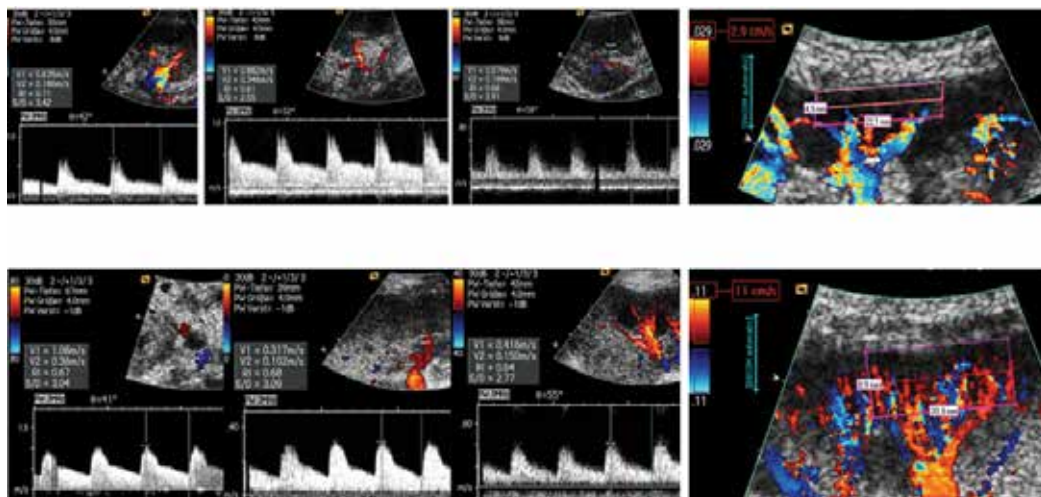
Two renal transplants compared: upper line insufficient kidney with serum creatinine of 231 $\mu\text{mol/l}$ and normal kidney with a serum creatinine of 70 $\mu\text{mol/l}$ in the lower line. Left: RI measurement in three cortical arteries. Right: Color Doppler sonograms. Insufficient kidney displays a pronounced loss of peripheral perfusion despite more sensible color Doppler setting compared to the kidney below. RI mean values are 0,66 for both transplants
